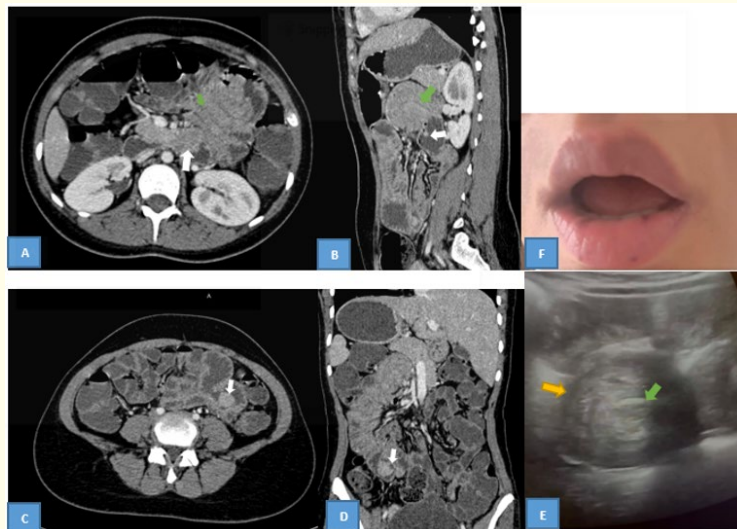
CT scan of the abdomen and pelvis with intravenous contrast on the axial plan (A) with sagittal (B) and coronal reconstruction (C) showing duodeno-jejunal intussusception and jejuno-jejunal containing several polyps (white arrows). (D) Sonographic ultrasound (E) appearance of an ileo-ileal invagination. Longitudinal section of the intussusception sausage showing successive layers of the digestive wall (yellow arrow). In the center, invaginated mesenteric fat with vessels (green arrow).
